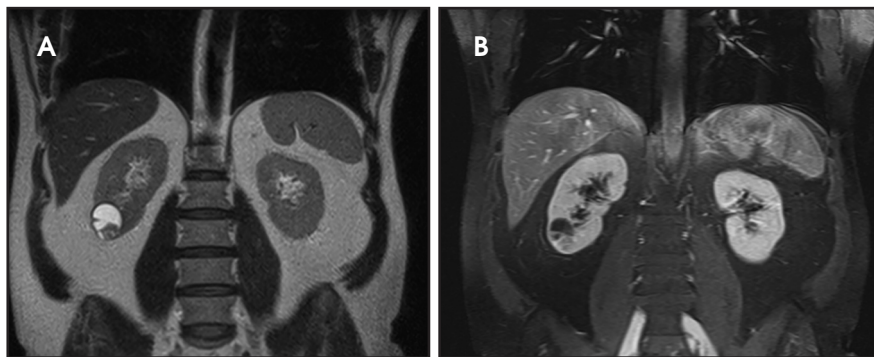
Cystic RCC with a mural nodule in a 54-year-old man. Coronal T2-weighted (A) and contrast-enhanced (B) MR images demonstrate a cystic mass containing an enhancing mural nodule in the periphery. This was proven to be a cystic clear cell RCC with mural nodule.
